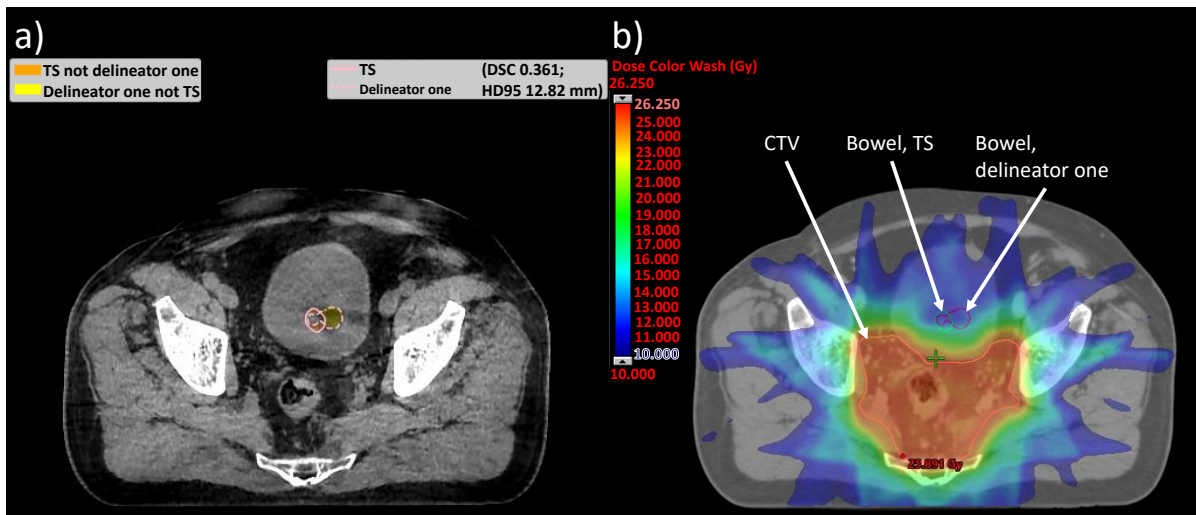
a) Output from the Python script calculating Dice Similarity Coefficients (DSCs) and 95<sup>th</sup> Hausdorff Distances (HD95s) between the bowel segmented by delineator one (pink dashed lines) and TotalSegmentator (AI) (pink solid lines) in one CBCT slice resulting in a low DSC. Coloured area represents non-overlapping area. b) Dose distribution within the same CBCT slice with delineated CTV (pink) and the bowel segmented by delineator one (red) and TotalSegmentator (AI, green).
